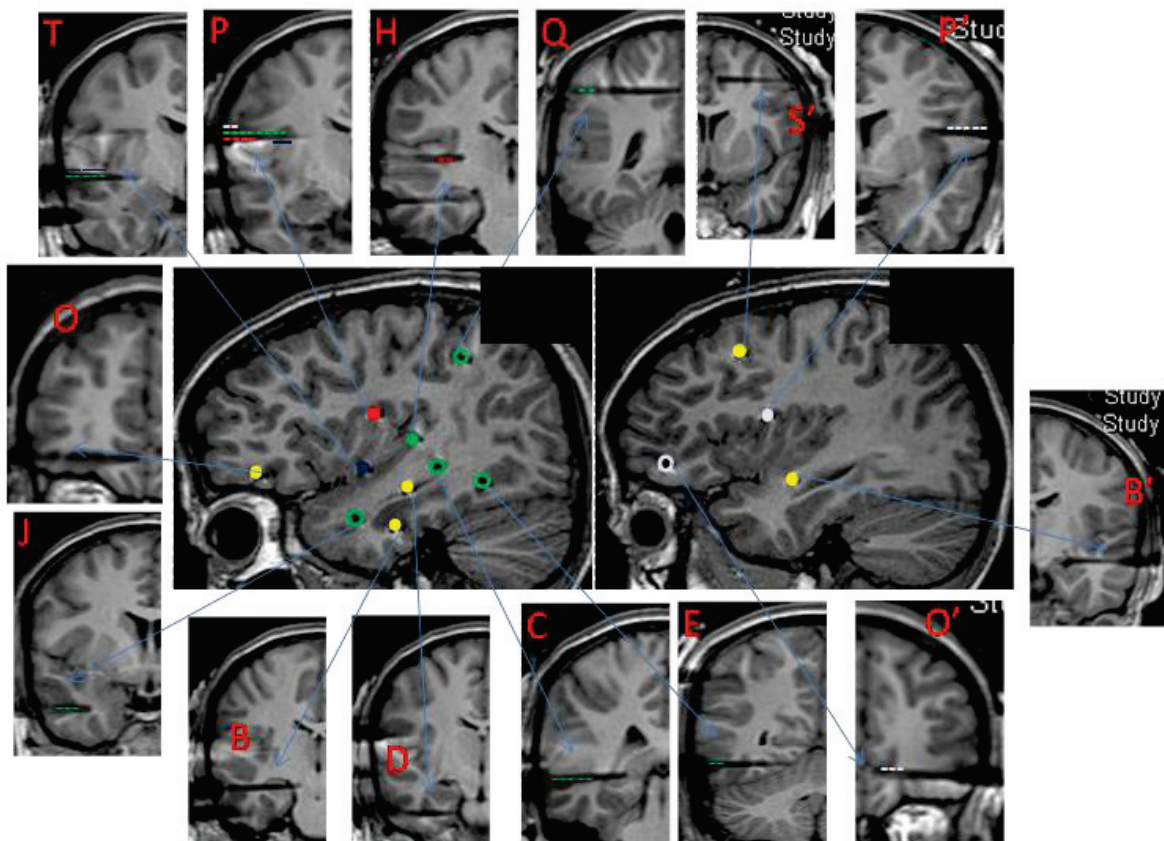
6: Patient 6 MRI with electrodes in place (Left and right hemispheres). Central sagittal image: each insular electrode is represented by a unique colored solid circle; non-insular electrodes are represented by empty circles with the color of each of the insular electrode they are responding to. Yellow solid circles are for non responding electrodes. Peripheral coronal images: a cross-section of each electrode with its name and its responding contacts (responses are indicated by color coded dotted lines, representing the color of the corresponding stimulated insular electrode).
